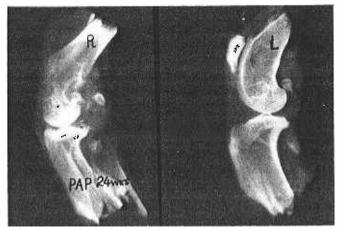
Lateral roentgenograms of control left knee and papain injected right knee twenty-four weeks after the last intra-articular injection. Note the marked narrowing of the joint space, subchondral sclerosis and lipping of the tibial articular margins on the right side.
